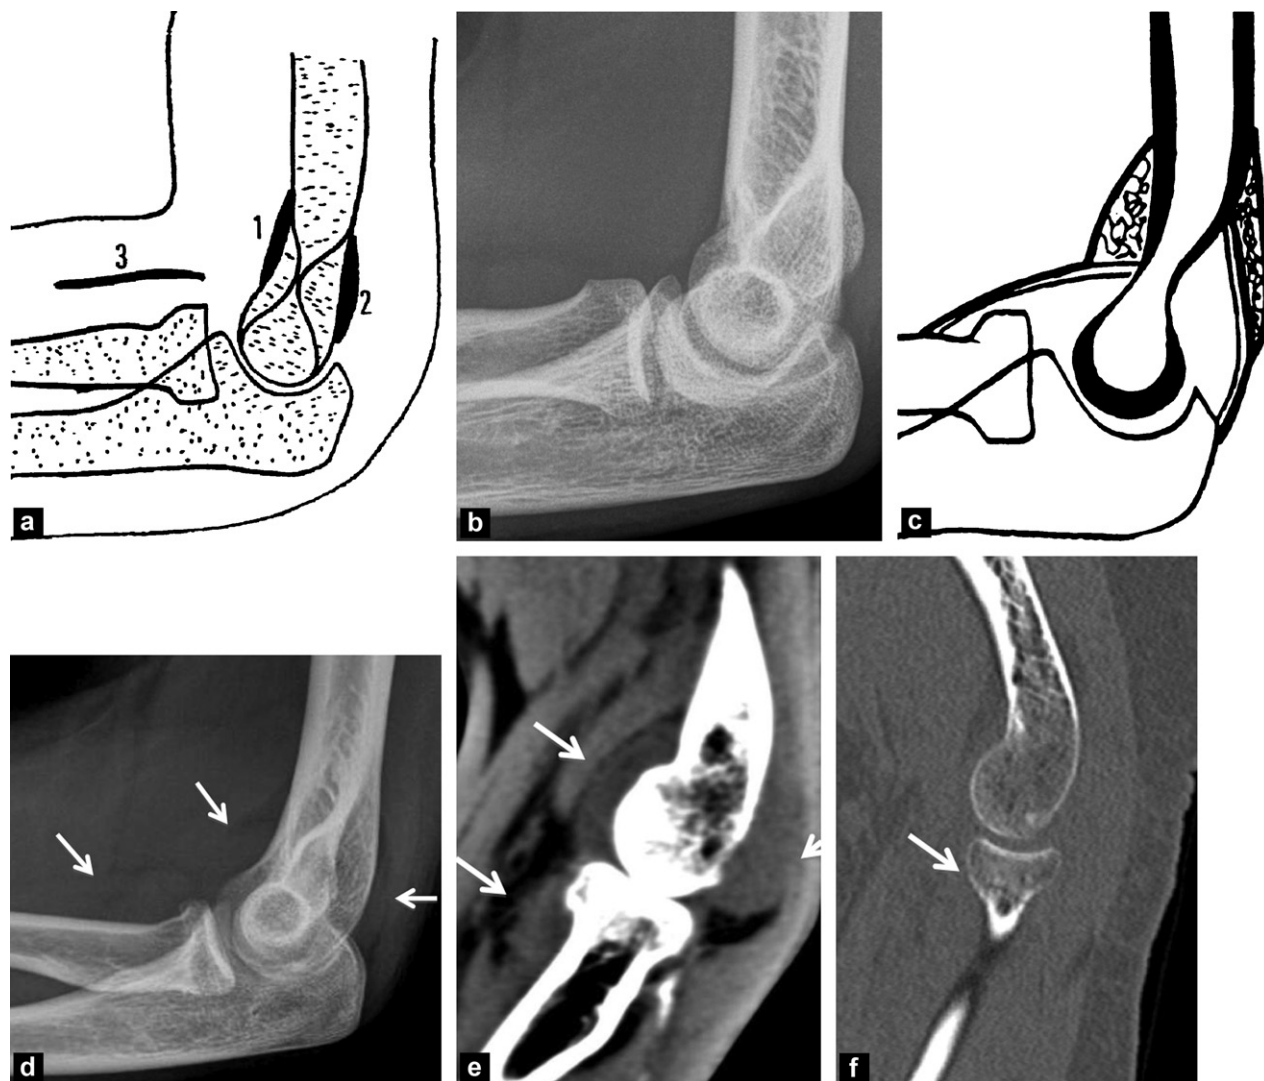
Intra-articular effusion of the elbow. a: normal elbow Three fat pads should be searched for (1: anterior; 2: posterior; 3: pronator teres). They are not visible or slight in the normal state; b: correspondent X-ray (profile); c: effusion: the fat pads are displaced; d: traumatic elbow, the effusion is fully visible; e and f: CT (sagittal reformat) confirms the effusion and the cause is found, here a non-shifted, subtle fracture of the radial head.
